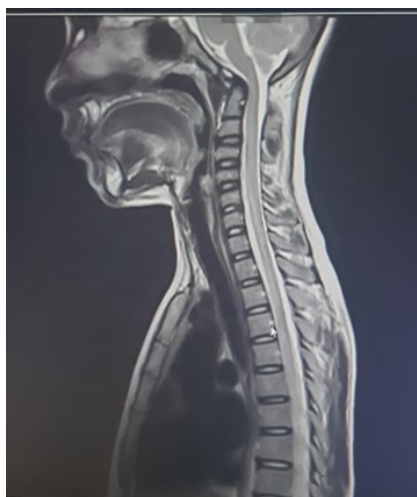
MRI SPINE-Long segment, Linear, Intramedullary T2 hyperintensity noted in SC-C2 to D4 vertebral body with mild cord swelling
